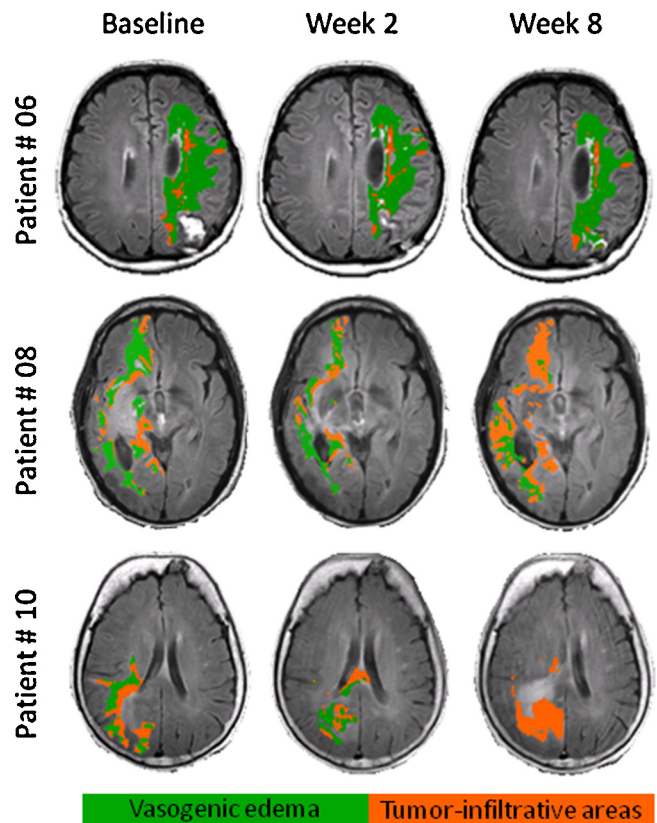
Classification results of the non-enhancing FLAIR lesion area during therapy obtained from three patients at baseline, two and eight weeks following initiation of bevacizumab therapy.
